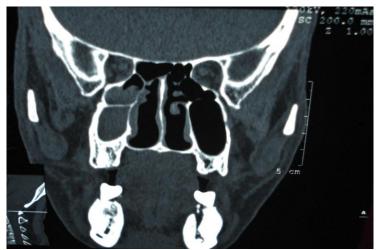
CT scan PNS coronal view showing soft tissue mass shadow in right maxillary and ethmoidal sinus
